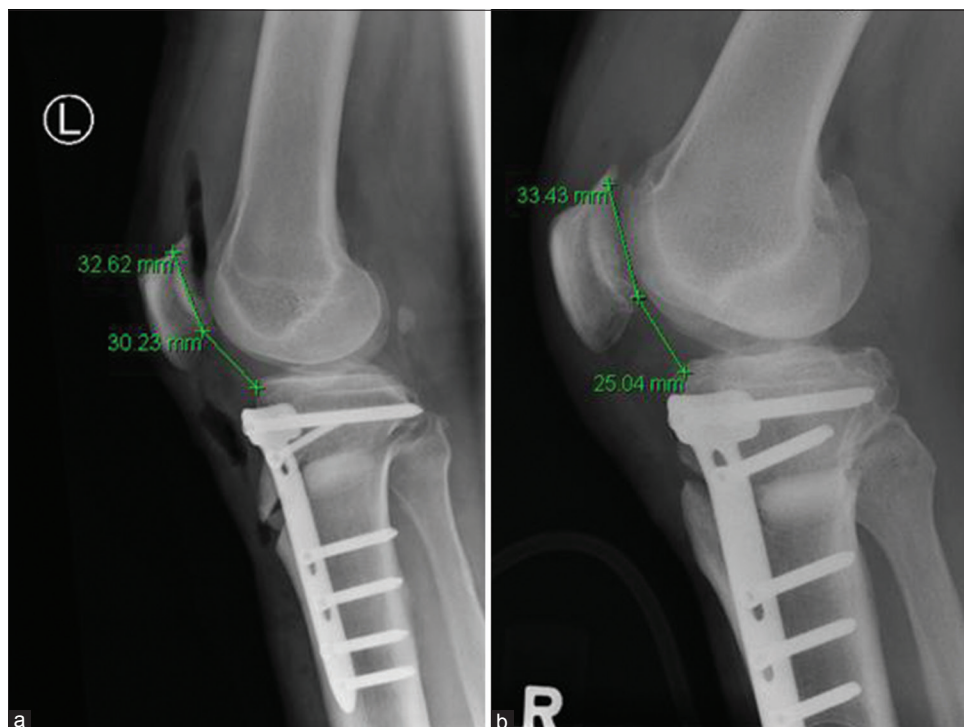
X-ray knee joint lateral views showing (a) Infra-tubercle osteotomy, (b) supra-tubercle osteotomy
